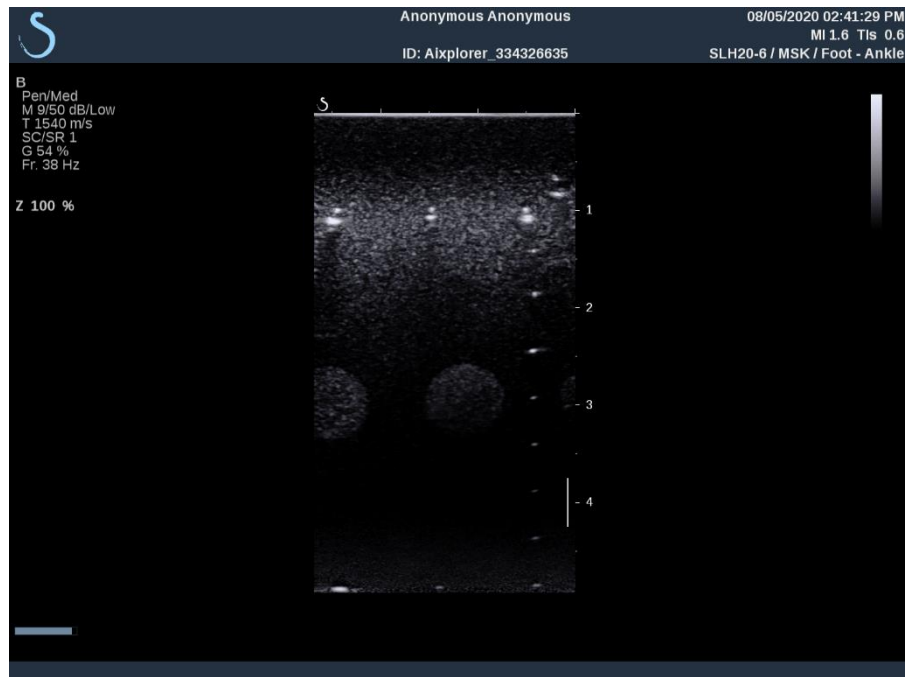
Ultrasound image used for the vertical/horizontal distance check. Captured with the stock SLH20-6 probe.
